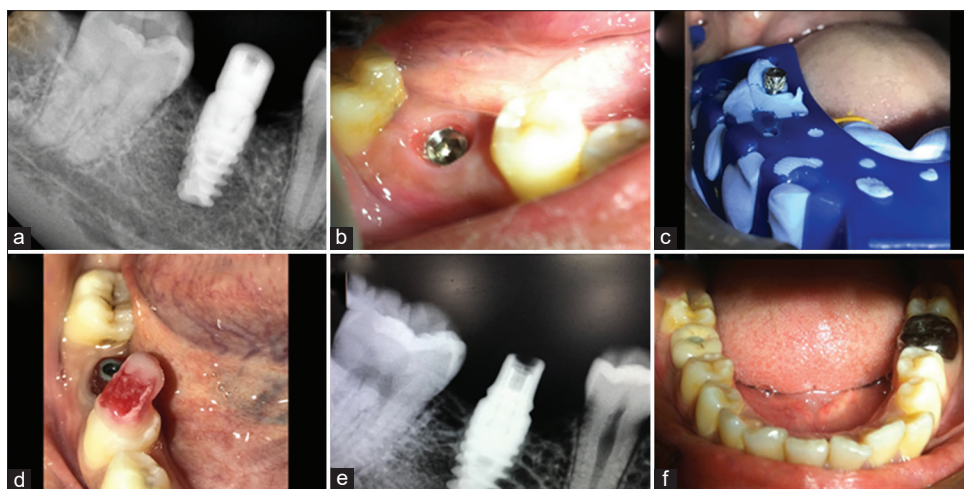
Threemonths post-reimplantation (a) intraoral periapical (IOPA), (b) soft-tissue healing, (c) open tray impression, (d) verification jig, (e) IOPA to check sitting of abutment, (f) placement of cement and screw-retained final crown
